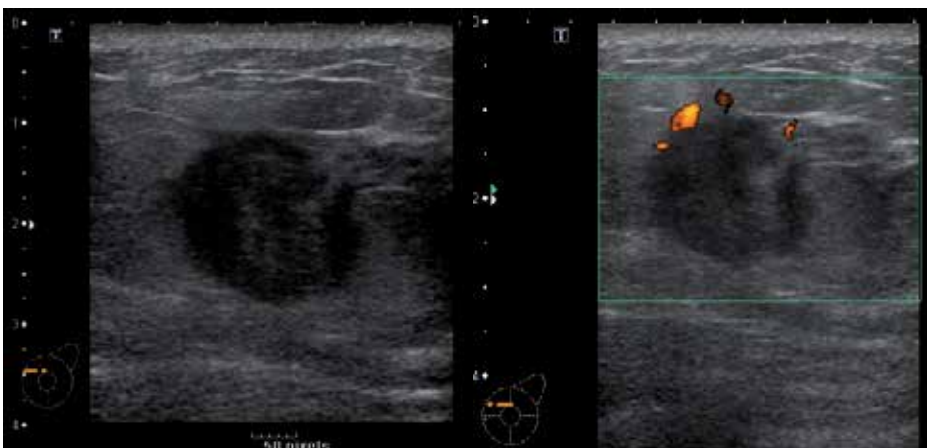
A first representative case of IDC, Ultrasound; B-mode and power Doppler.
